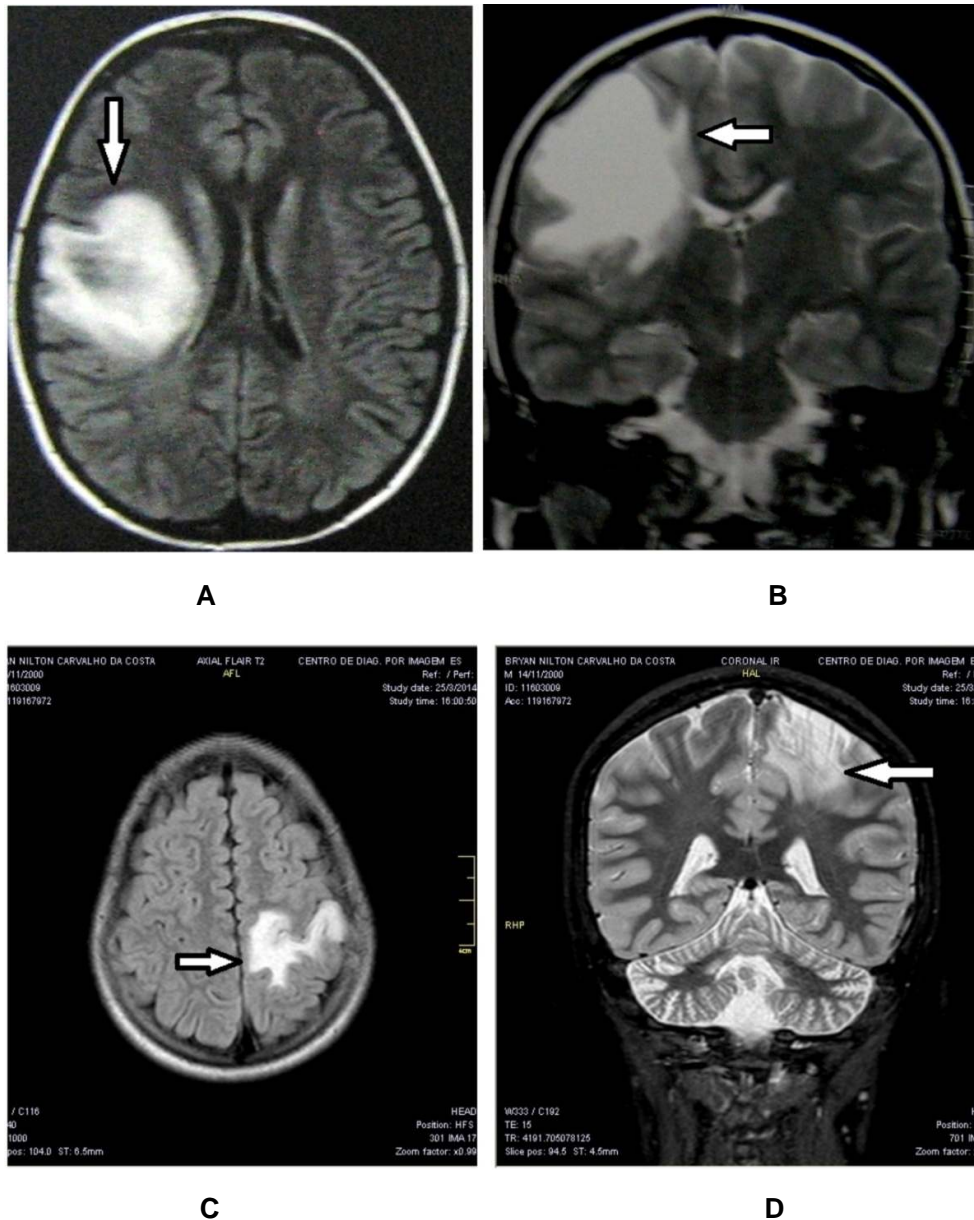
A and B (Case 3) - FLAIR sequence, axial (A) and T2-weighted sequence, coronal (B): inhomogeneous hyperintense lesion with moderate tumefactive effect on justacortical and deep white matter.
